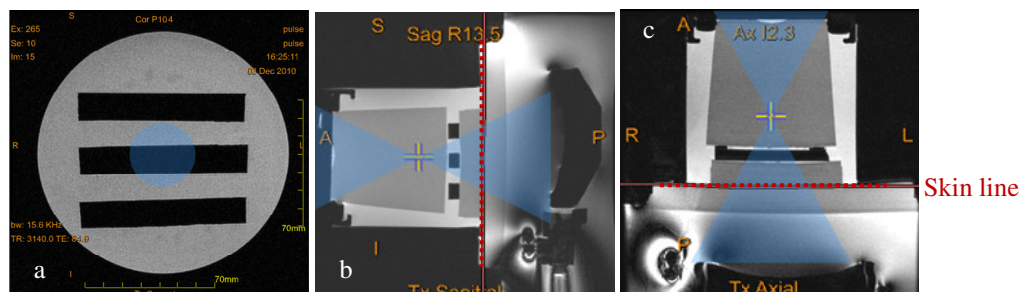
ExAblate 2000 System: MR images showing the experimental setup for the trans-costal sonications (a- coronal, b- sagittal and c- axial planes).
